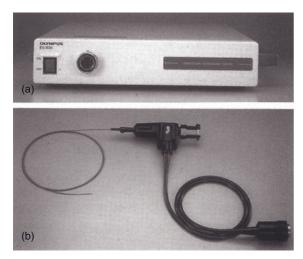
Endoscopic Ultrasound Center (EU-M2000), Probe Driving Unit (MH-240).
